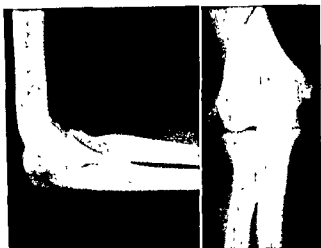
(Case 2) Anteroposterior and lateral roentgenograms showing a calcific density lateral and distal to the lateral epicondyle of the humerus.
